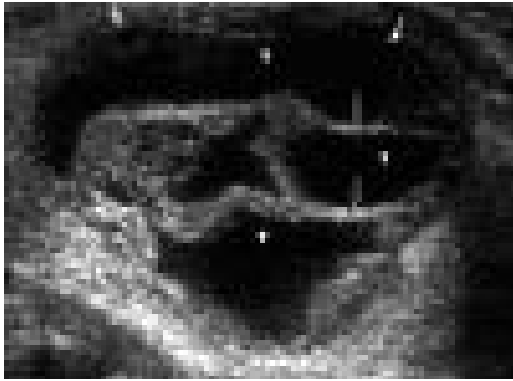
Longitudinal grey scale sonogram shows a well-defined heterogeneous thyroid nodule with a large cystic component and septation. These features are compatible with a benign hyperplastic nodule.
